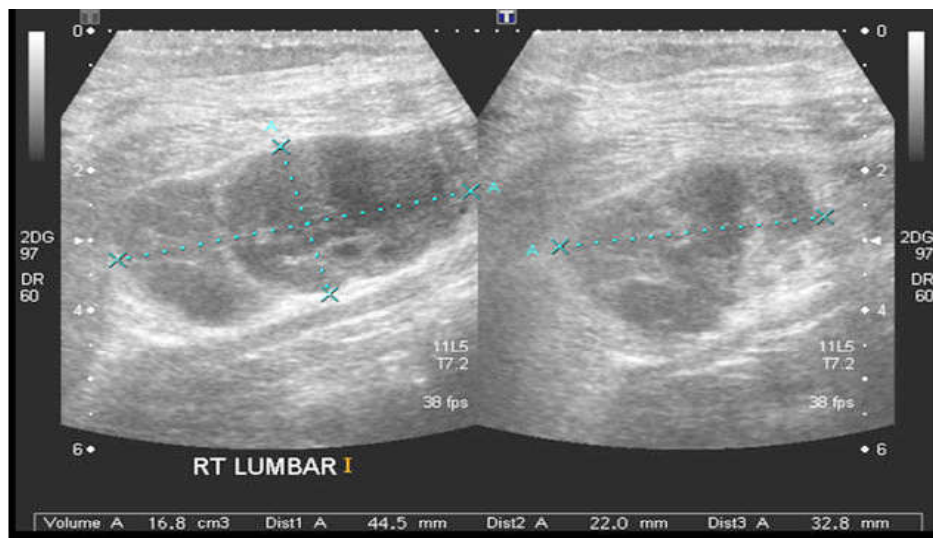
Ultrasound Abdomen
